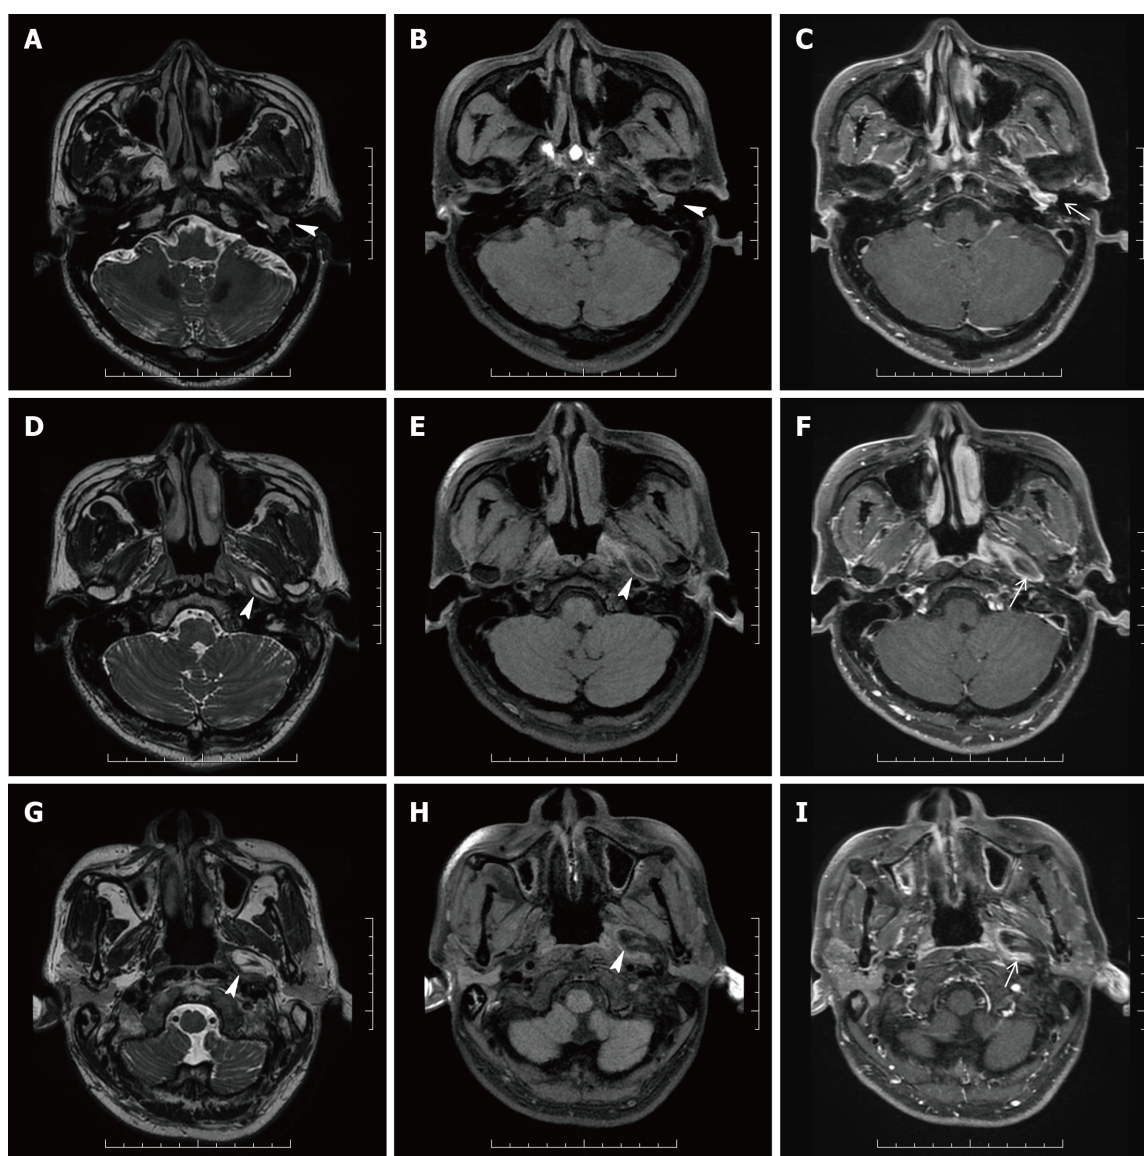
Magnetic resonance imaging of the patient's head and neck. A, D, G: Three-dimensional (3D) T2 weighted image (WI); B, E, H: Fat suppression (FS) 3D T1WI; C, F, I: FS 3D T1WI with contrast (C+); A-C: Magnetic resonance (MR) images in the transverse plane showed the part of the mass which was a homogeneous lesion with slightly higher signal intensity and with enhancement (white arrowheads) in the tympanum and external auditory canal; D-F: MR images in the transverse plane showed the part of the mass which was a well-defined, homogeneous lesion with high signal intensity along the left eustachian tube (white arrowheads), and on FS 3D T1WI, a lesion with decreased signal intensity consistent with macroscopic fat and with a contrast-enhancing rim (black arrowhead) was seen.
